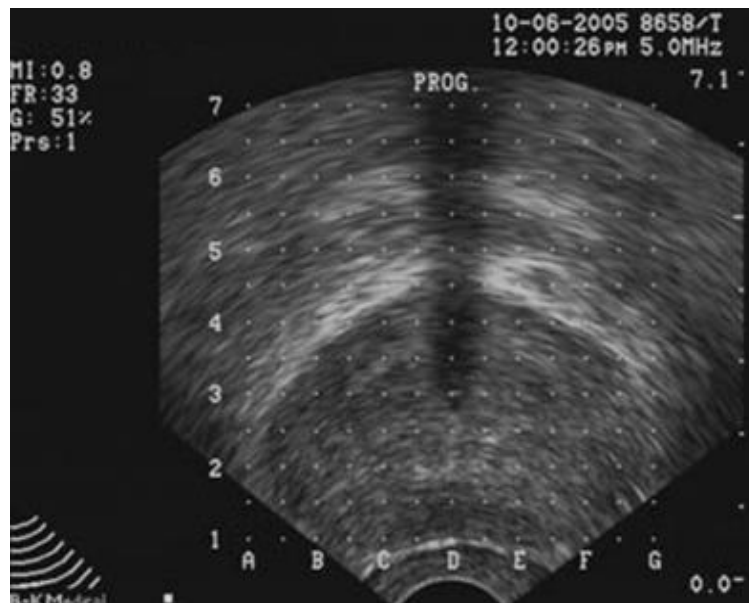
Shows a trans rectal ultrasound image of normal prostate(Ayala AG,1989)
